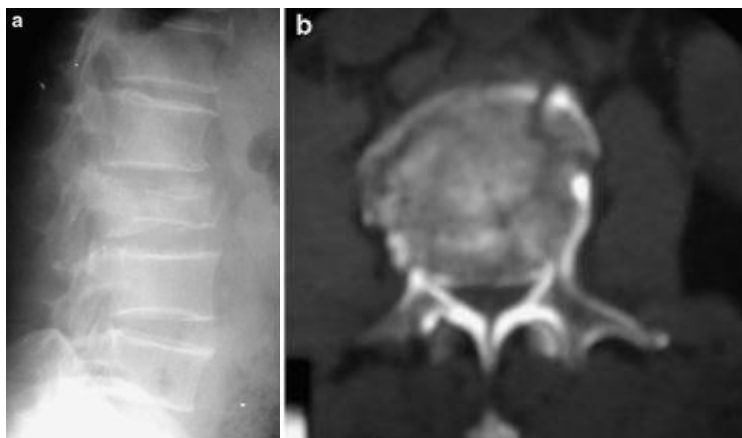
a) Lateral radiograph shows an L2 burst fracture in a 59-year-old man. b) Axial CT image demonstrates 70% canal compromise. Image from Altay M. et al. 2007.
